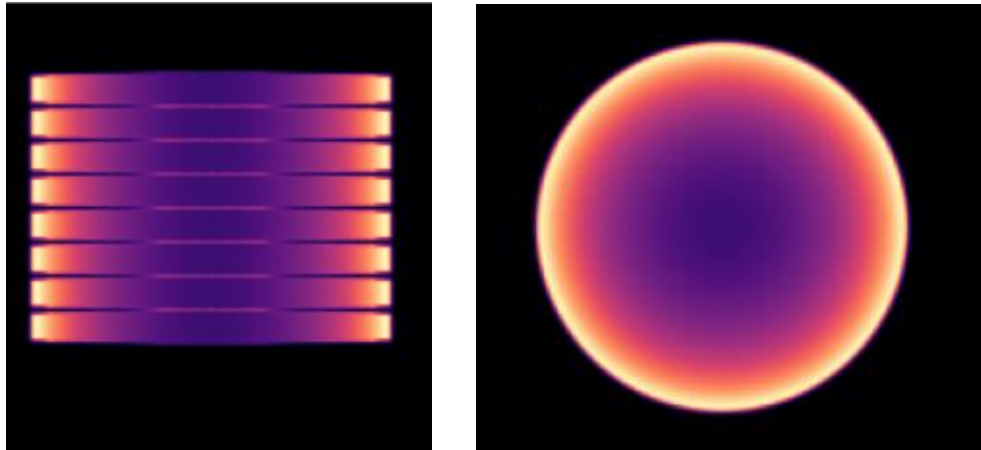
Example of a three-dimensional attenuation curve for a CT scan in a water cylinder with a diameter of 32 cm. left: z-x view, right: x-y view.
